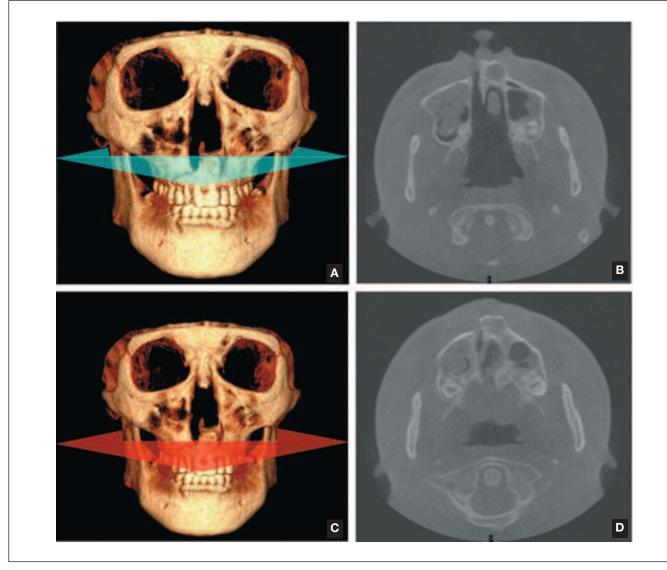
Three-year posttreatment CBCT images showing different areas of clefting; A, C, A volume-rendering 3-dimensional computed tomography; B, D, multiplanar reconstruction (MPR) image.
